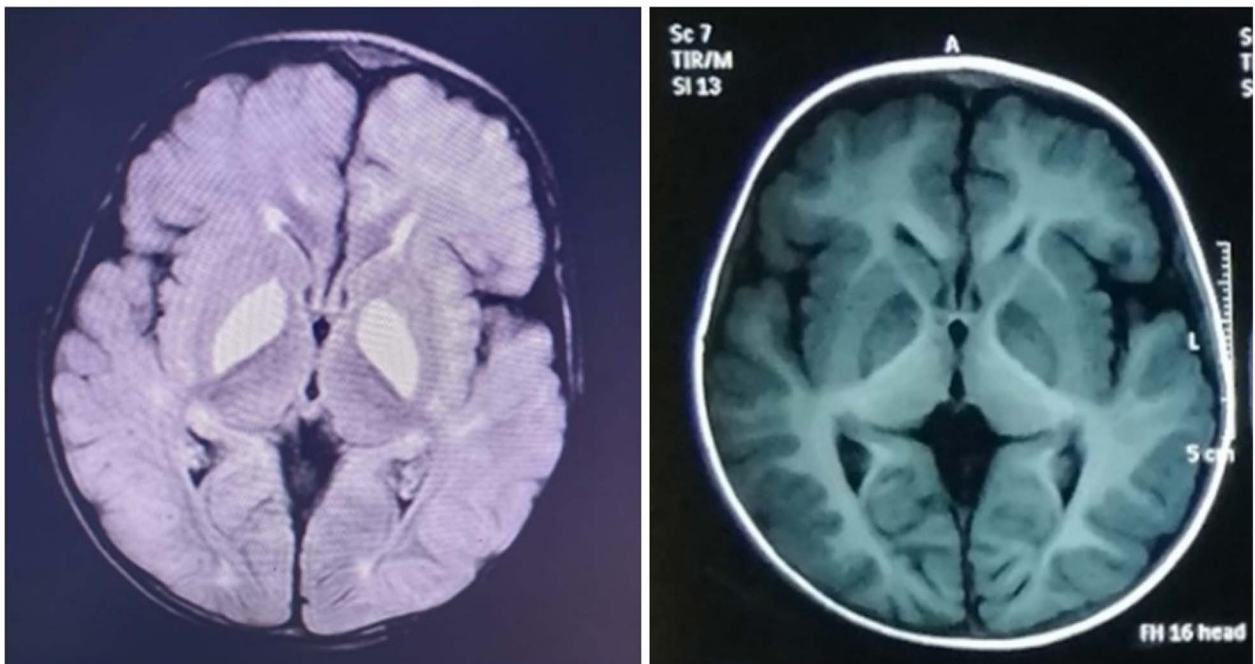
MRI brain images showing bilateral symmetrical T2 FLAIR high signal intensity (black arrow) and T1 low signal intensity (white arrow) involving the globus pallidi
